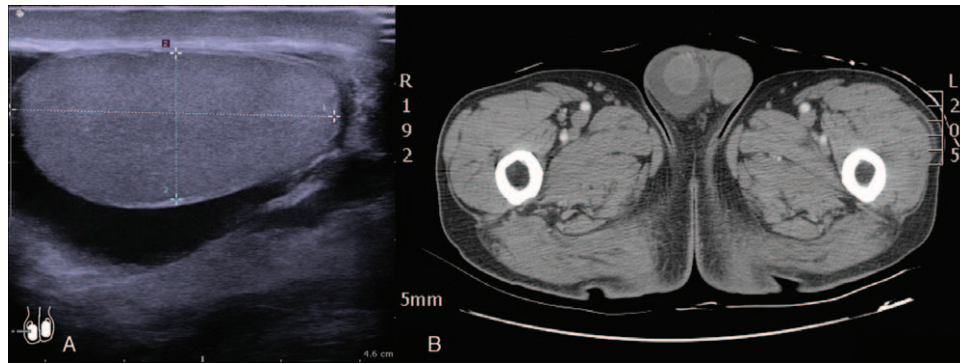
Scrotal imaging. (A) Ultrasonography showed a 41.3×18.7 mm egg-shaped testis with anechoic fluid accumulation in the right scrotum. (B) Computed tomography scan revealed enlarged right scrotum with homogeneous fluid collections around the testis without inflammatory, ischemic or necrotic change.
